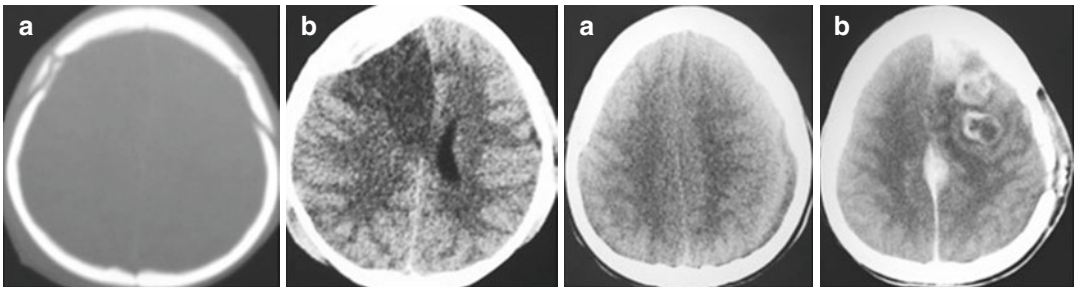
Secondary ischemia following closed head trauma in 10-year-old boy. The patient was brought to the emergency room after a traffic accident. The patient was unconscious and had no lateralized signs. CT scan shows right frontal fragment fracture (a). Epidural hematoma and ischemia developed 2 days later (b). The hematoma was drained. Abscess in left hemisphere in 15-year-old female. The patient was brought to the emergency room
